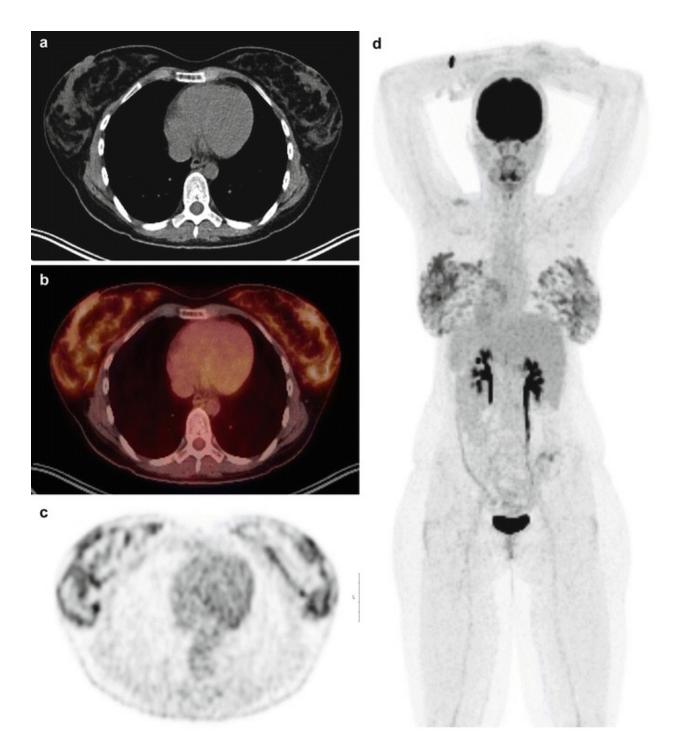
27 year old female patient undergoing PET/CT after successful treatment of hodgkin lymphoma for tumor recurrence diagnostics. Morphological CT (a), fused PET/CT (b) and PET images (c) as well as a PET maximum intensity projection image (d) are displayed. A strong tracer uptake of the glandular mammary tissue can be observed in both breasts due to breastfeeding
